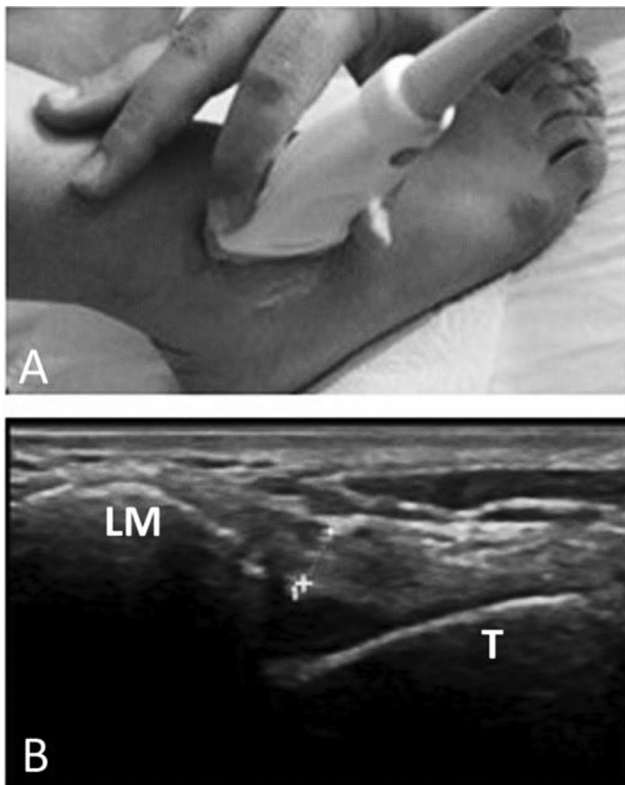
A longitudinal ultrasonographic image of the anterior talofibular ligament. (A) The linear probe positioned in a slightly oblique position from the lateral malleolus (LM) to the talus (T). (B) The ligament thickness measured halfway between the two bony landmarks of the ankle.
